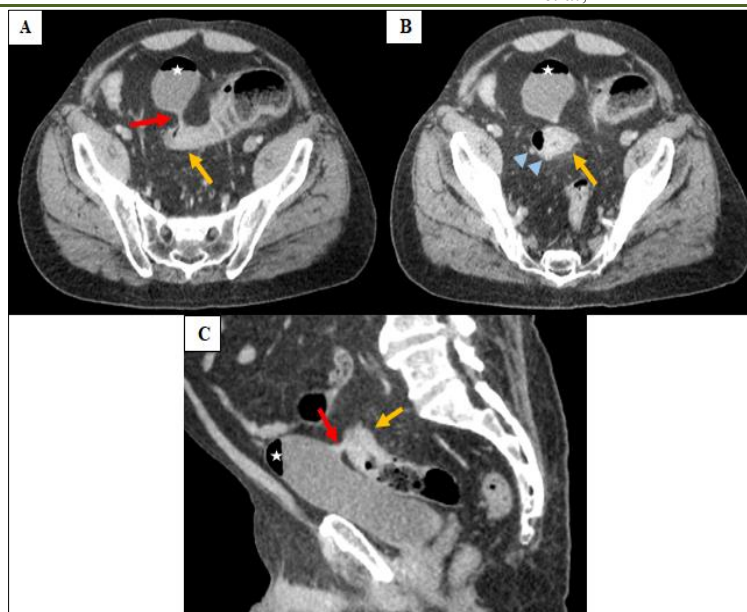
Abdominal contrast-enhanced CT scan in axial (A, B) and sagittal (C) plans demonstrating circumferential and irregular wall thickening of the rectosigmoid junction (yellow arrows) causing luminal narrowing and upstream dilation, associated with a fistulous tract communicating between the involved section of the sigmoid and the bladder (red arrows) which contained an air-fluid level (white asterisk). Adjacent colonic diverticulosis was noted (blue head arrows)
